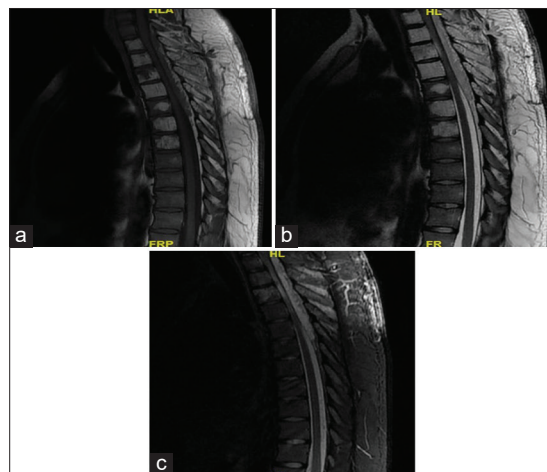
MRI dorsal spine Sagittal view (a) T1W image (b) T2W image (c) STIR image showing altered bone marrow signal intensity involving D1–D7 vertebrae appearing hypointense on both T1W and T2W images with contiguous involvement of posterior element. Patchy residual normal bone marrow signal noted in D1–D7 vertebrae. Extra dural/epidural lesion arising from C7 to D8 vertebrae appearing hypointense on T1W and hyperintense on T2W/STIR causing significant mass effect on cervicodorsal spinal cord. Intracord T2W/STIR hyperintense signal at D2–D3 level.
